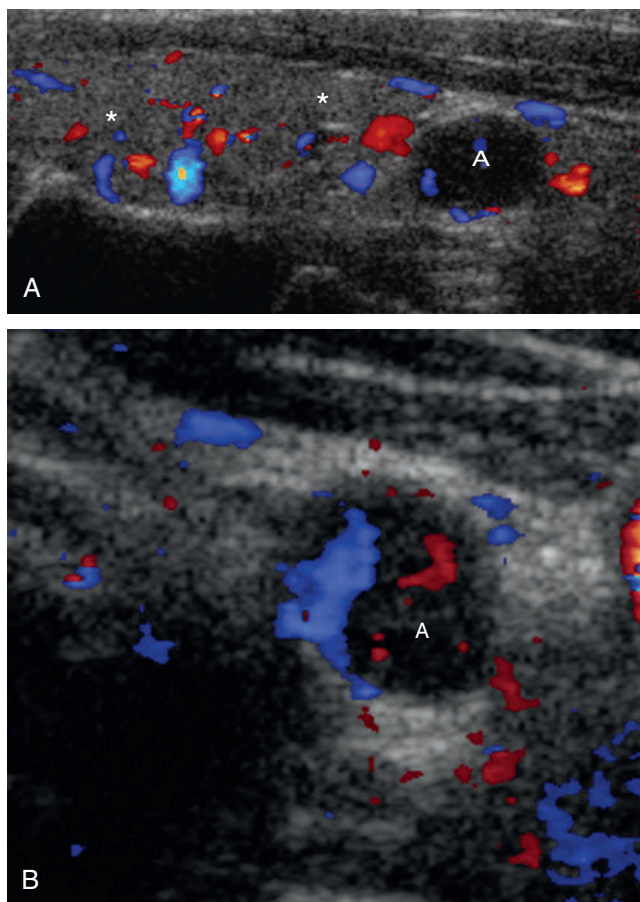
Classic parathyroid adenoma identified on ultrasonography.
